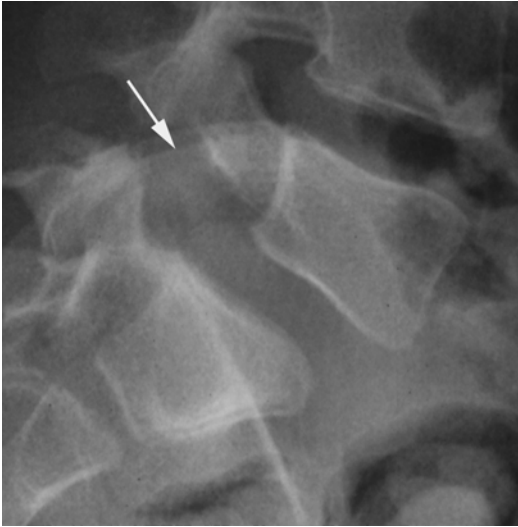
Spondylolysis (*arrow*) and a low-grade L5 slip on a standing lateral radiograph
